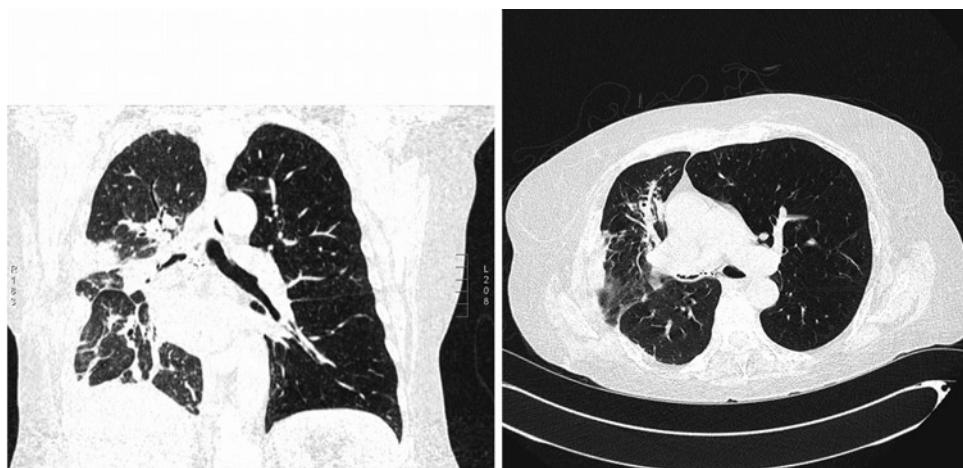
HRCT chest demonstrating stenosis of the bronchial anastomosis following a single right lung transplant for COPD.
